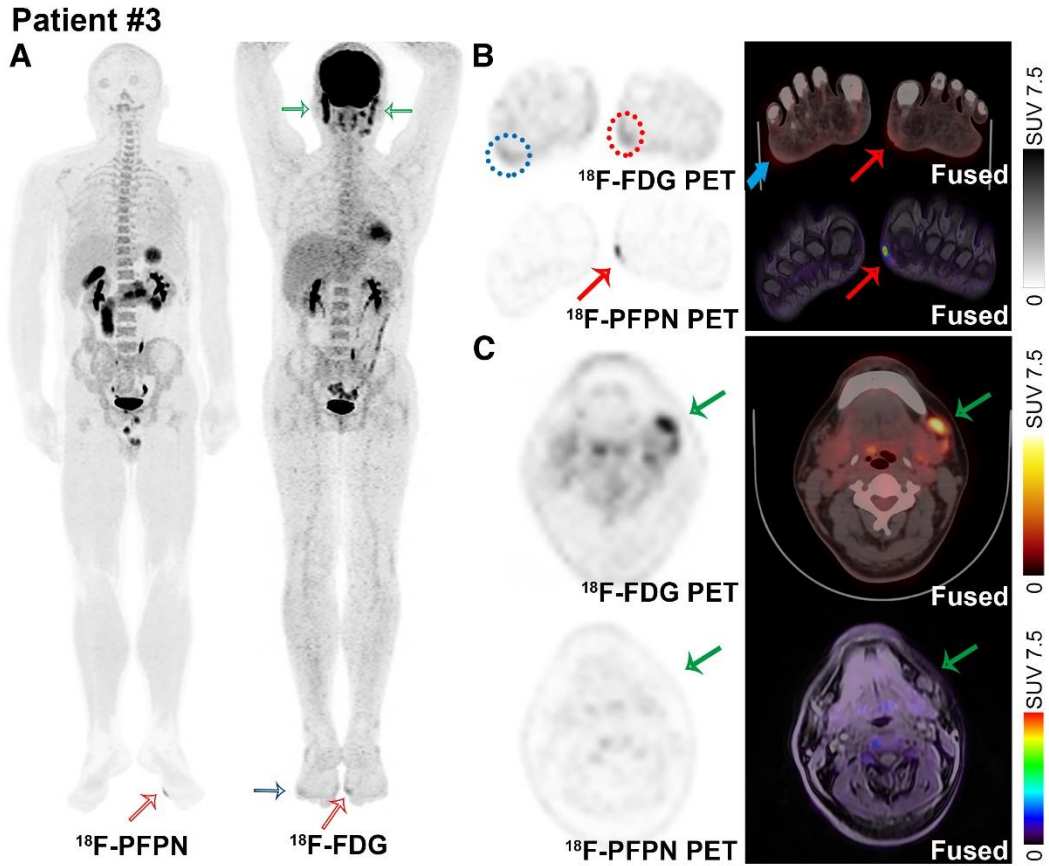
A 40-year-old man sought medical attention for a growing pigmented lesion located on the arch of the left foot.  $^{18}\text{F}$ -FDG PET images (A and B) revealed mild tracer accumulations in the left anterior arch (red circle and red arrows; SUVmax: 3.3) and the lateral margin of the right foot (blue circle and blue arrows; SUVmax: 2.7).  $^{18}\text{F}$ -PFPN PET was capable of providing a clear delineation of the lesion located in the left foot, which showed an avid tracer uptake (SUVmax: 5.0), but did not identify any lesion in the right foot. The results of pathology identified the left foot lesion as a nodular ulcerated MM (thickness: 1.2 mm; pathological T stage: pT2b). Interestingly, there was an intense  $^{18}\text{F}$ -FDG uptake in the cervical lymph nodes (C, green arrows: SUVmax: 3.0–12.6) which, however, did not show significant  $^{18}\text{F}$ -PFPN uptake. Collectively, these findings ruled out that these lesions were metastases from MM;  $^{18}\text{F}$ -FDG PET-positive nodes likely had a reactive inflammatory nature.
